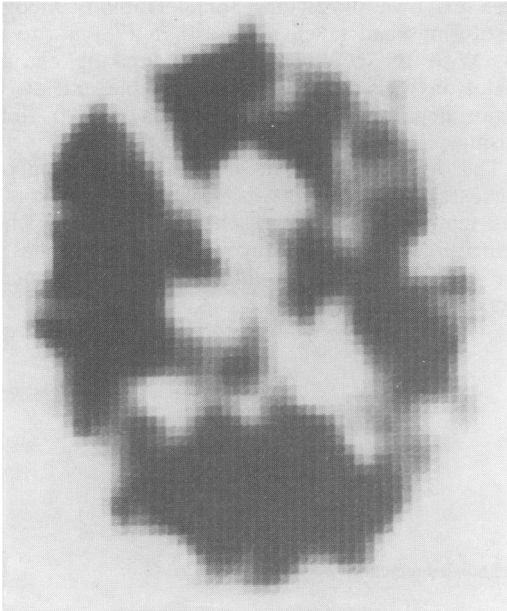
An elderly woman with dementia of the Alzheimer type produced this SPECT cross-section with technetium-99m HM-PAO. The banana-shaped posterior defect is now becoming a well-recognized feature in this condition.
